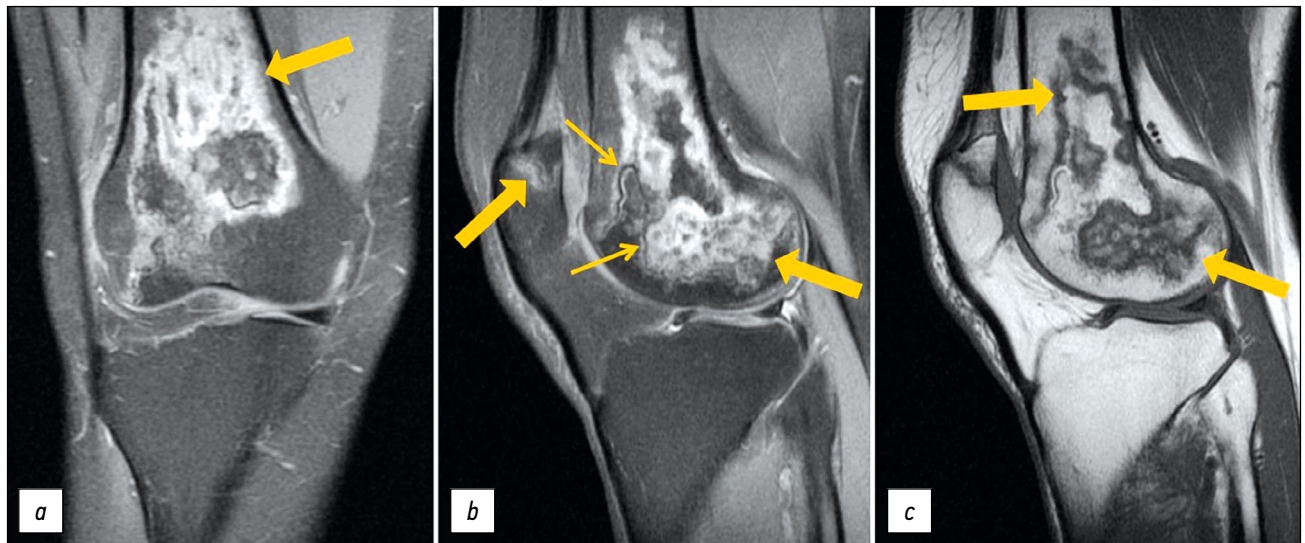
Primary MRI of the right knee joint: PDWI with fat suppression in the coronal (a) and sagittal (b) plane and T1WI in the sagittal plane (c). Thick arrows indicate areas of bone marrow edema in the form of a heterogeneous, irregularly shaped (“geographic”) MRI signal of femoral condyles and patella; thin arrows indicate the “double line” sign in the form of internal hyperintense (granulation tissue) and external hypointense (osteosclerosis) lines on PDWI.
